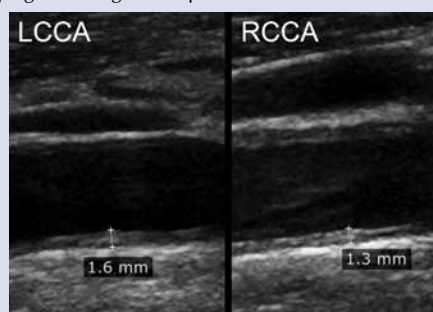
Doppler ultrasound of carotid arteries. LCCA IMT: 1.6 mm; RCCA IMT: 1.3 mm
